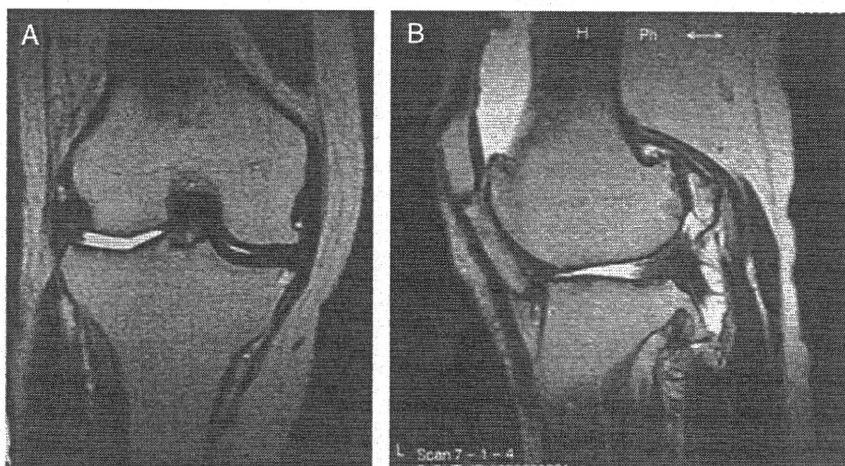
A 59-year-old female: magnetic resonance imaging T2 views: (A) coronal view and (B) sagittal view. The articular cartilage on both the femur and tibia side disappeared.
